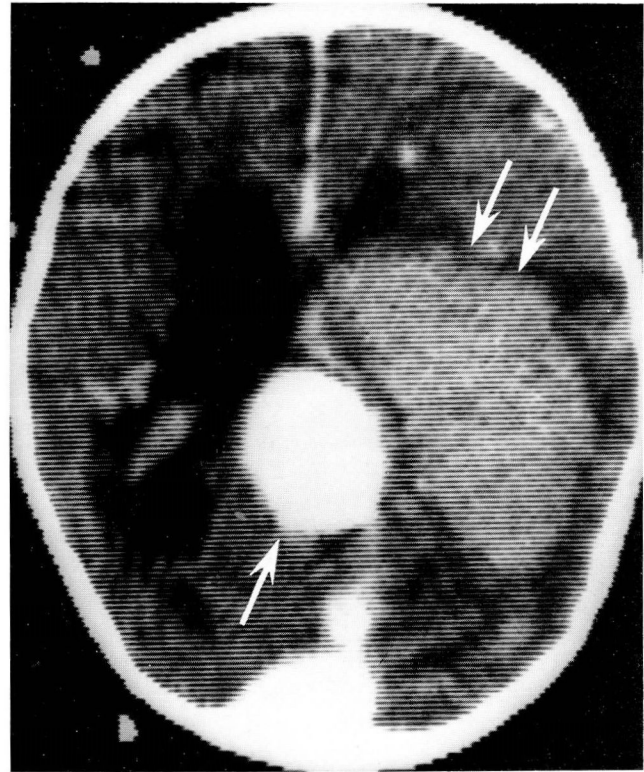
Case 4. Contrast computed tomography demonstrating a large vein of Galen aneurysm (*large arrow*). Note right temporal intracerebral hemorrhage (*double arrows*).
